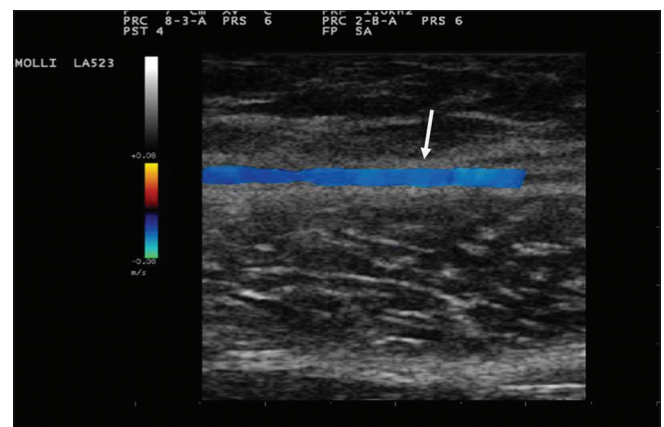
Ultrasound picture of the vein
